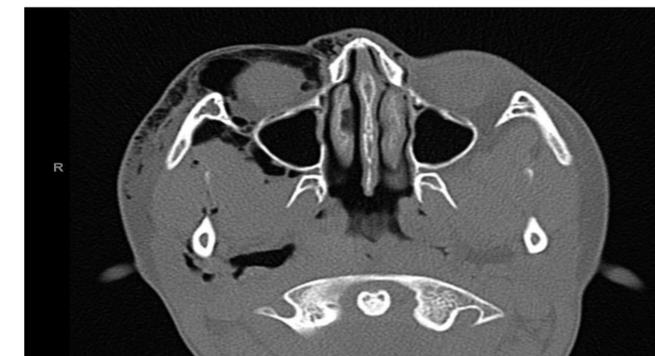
Axial CT scan showing subcutaneous free air in the right periorbital temporal and parapharyngeal spaces.
